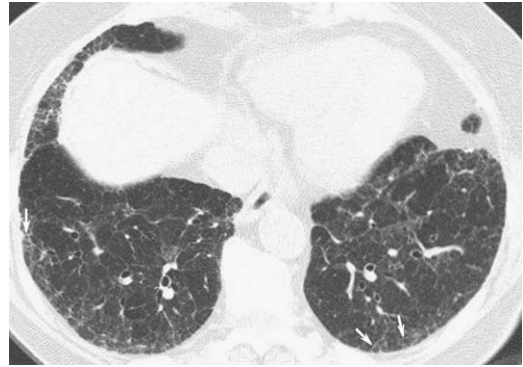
Intralobular interstitial thickening and reticulation in a patient with usual interstitial pneumonia—idiopathic pulmonary fibrosis. Axial HRCT shows bilateral subpleural coarse reticular opacities (*arrows*) representing a combination of intralobular interstitial thickening and irregular linear opacities. Surgical lung biopsy showed usual interstitial pneumonia.
